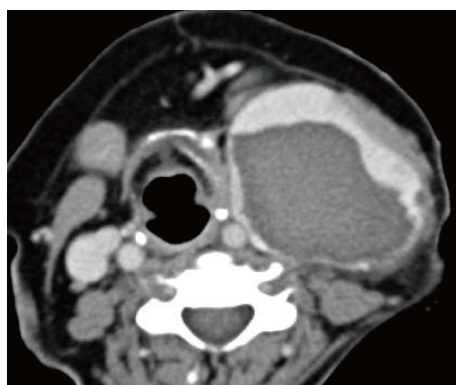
Transverse computed tomography of left internal jugular vein aneurysm.
